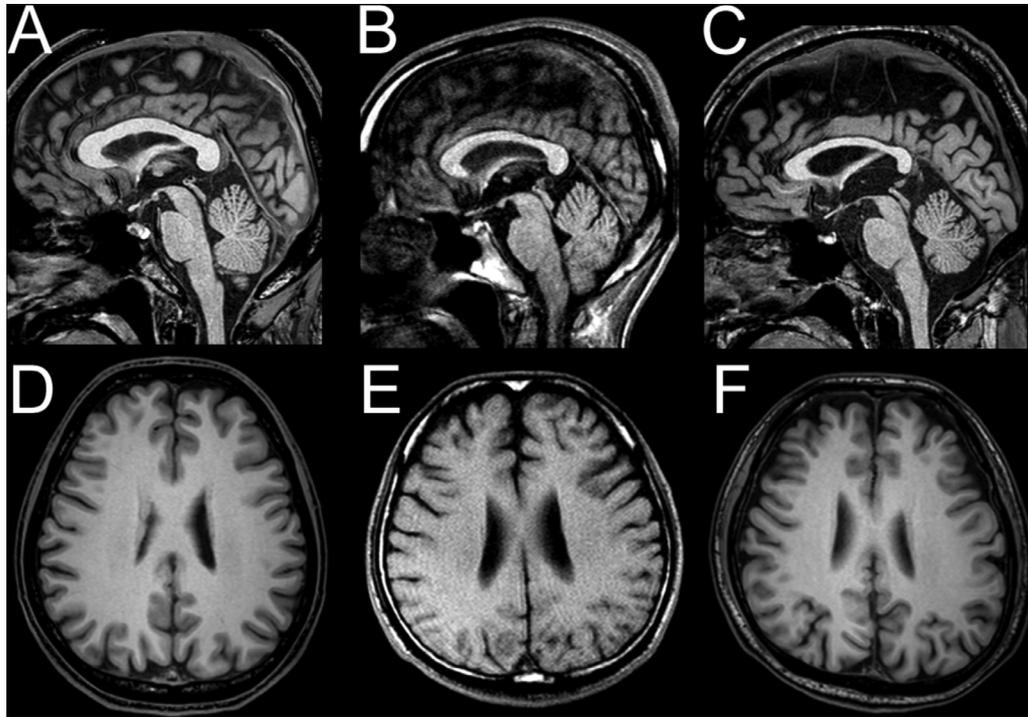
Brain sagittal and axial magnetization prepared rapid gradient-echo (MP-RAGE) MR imaging (MPRAGE) of a 39-year-old healthy control [A, D] and Patient 1, a 33-year-old BMD participant with schizophrenia [C, F]. Sagittal and axial T1-weighted spin echo imaging of Patient 2, a 37-year-old BMD participant with schizophrenia and mild mental retardation [B, E]. Images of Patient 1 show mild atrophy especially in the frontal lobe (E) and the corpus callosum, except for the splenium (B). In the images of Patient 2, diffuse marked atrophy is detected in the callosum and the cerebrum (C, F). Apparent dilatation of the cerebral sulcus and volume loss of the white matter are evidence of cerebral atrophy.
